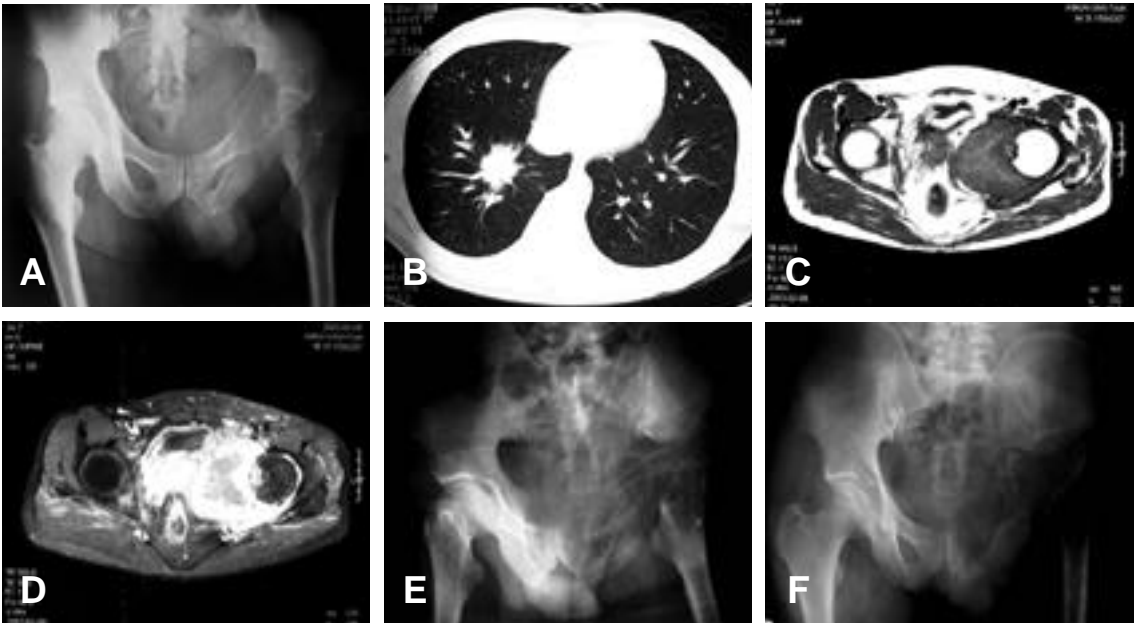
34 year-old-male. Lung cancer (A) Preoperative pelvis AP. Osteolytic lesion is shown on left acetabulum (B) Preoperative chest CT. 2.5 × 2.5 cm mass, suspected as primary origin, is shown on lung (right lower lobe) (C) (D) Preoperative pelvis axial MRI. 7 × 8 × 8 cm mass (low signal on T1 weighted image, high signal on T2 weighted image, high signal on postcontrast T1 weighted image) is shown on left acetabulum (E) Postoperative pelvis AP. Wide excision and girdlestone. (F) Follow-up pelvis AP: 1 year after operation
